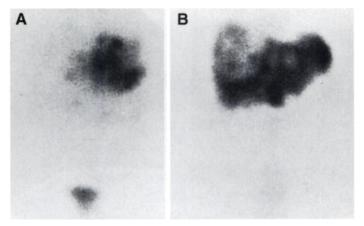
(A) lodine-131-MIBG scintigraphy 4 wk before the fifth $[1^{31}]MIBG$ therapy (7400 MBq) reveals multiple abnormal tumor uptake of the liver. (B) The ^{99m}Tc-colloid scintigram demonstrated nonfunctional liver tissue corresponding to the $[1^{31}]MIBG$ -avid areas beside normal colloid-avid tissue.
